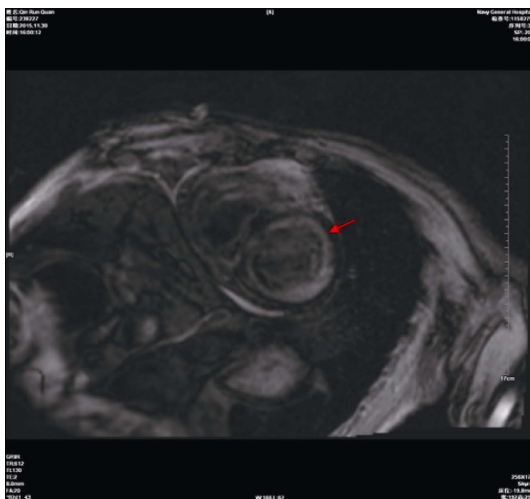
Cardiac magnetic resonance imaging presented delayed enhancement signal diffused in subendocardial of myocardial with post-injection the gadolinium (arrow).
